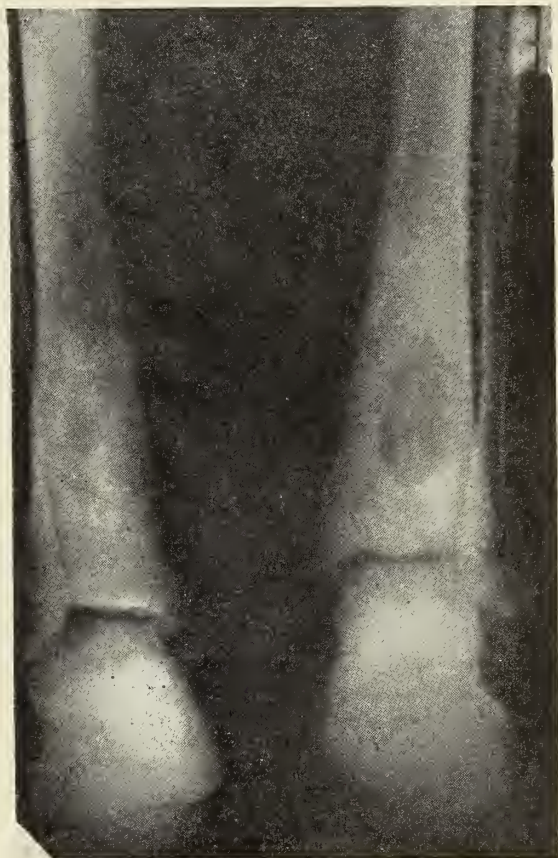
X-ray made on first admission showing bilateral lesions.
